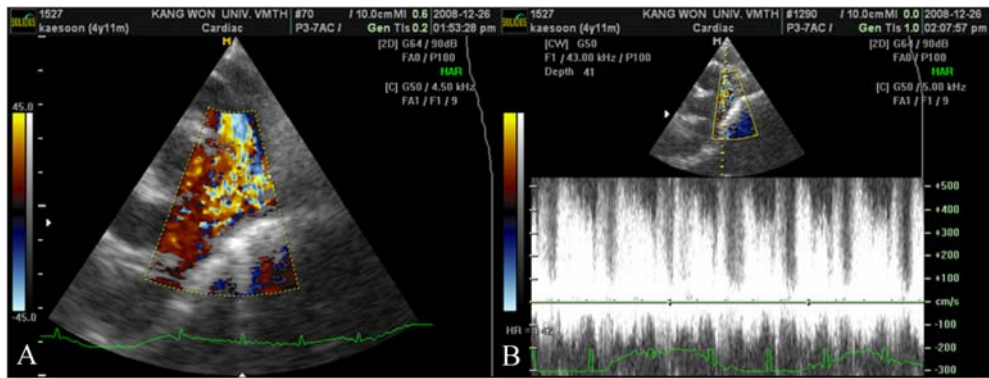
Color (A) and spectral (B) Doppler echocardiography revealed a shunt flow between the aorta and pulmonary artery.
